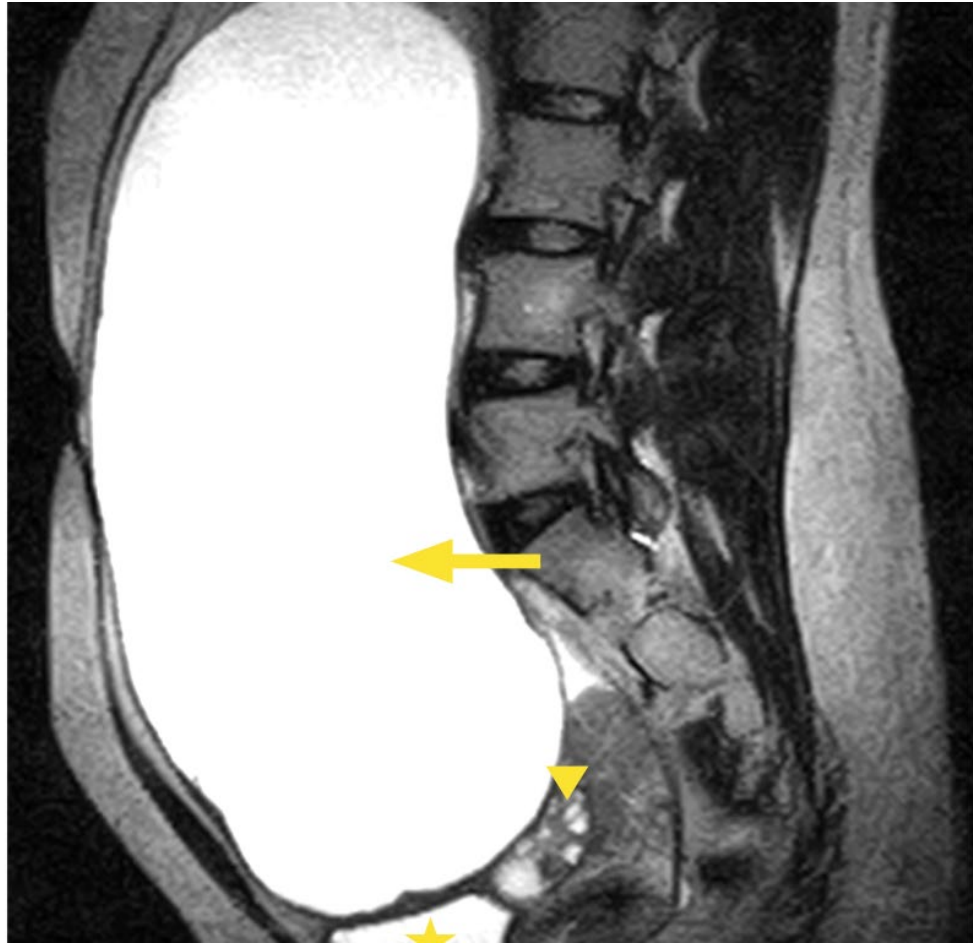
MRI image of the cystic lesion- T2 sag image.
